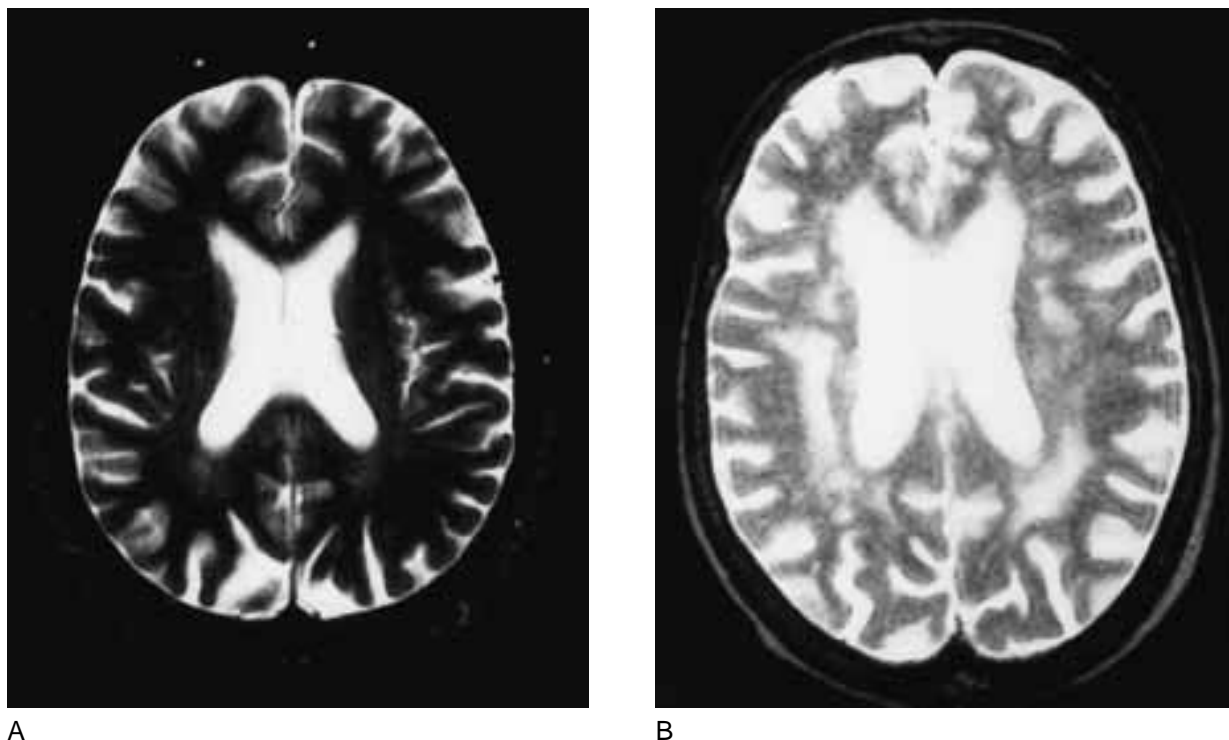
A. MRI of the brain in a 55-year old man three years after diagnosis of SCLC. T₂-weighted image shows no cortical atrophy and the absence of periventricular and subcortical leukoencephalopathy. B. MRI of the brain in a 69-year old woman seven years after diagnosis of SCLC. T₂-weighted image shows moderate cortical atrophy and the grade III periventricular and subcortical leukoencephalopathy.
